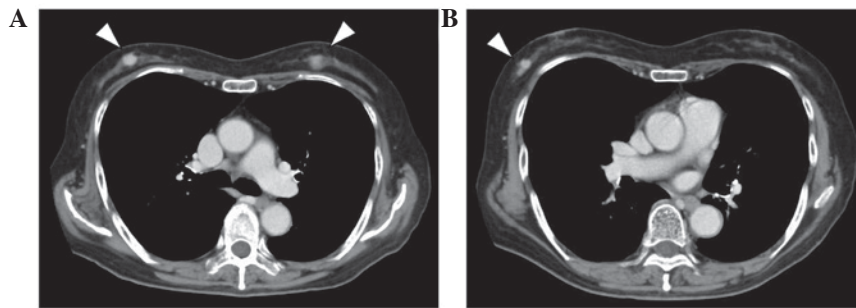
Contrast-enhanced computed tomography (CT). (A) CT scans revealed bilateral enhanced solid tumors (white arrowheads). (B) An additional tumor was revealed in the right breast (arrowhead).
